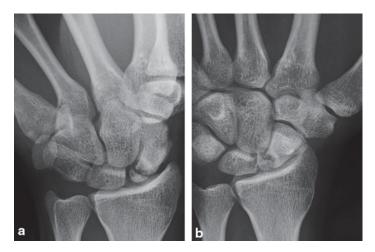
a–b X-rays of very small proximal pole nonunion. (Published with kind permission of ©Christophe Mathoulin 2015. All Rights Reserved)
